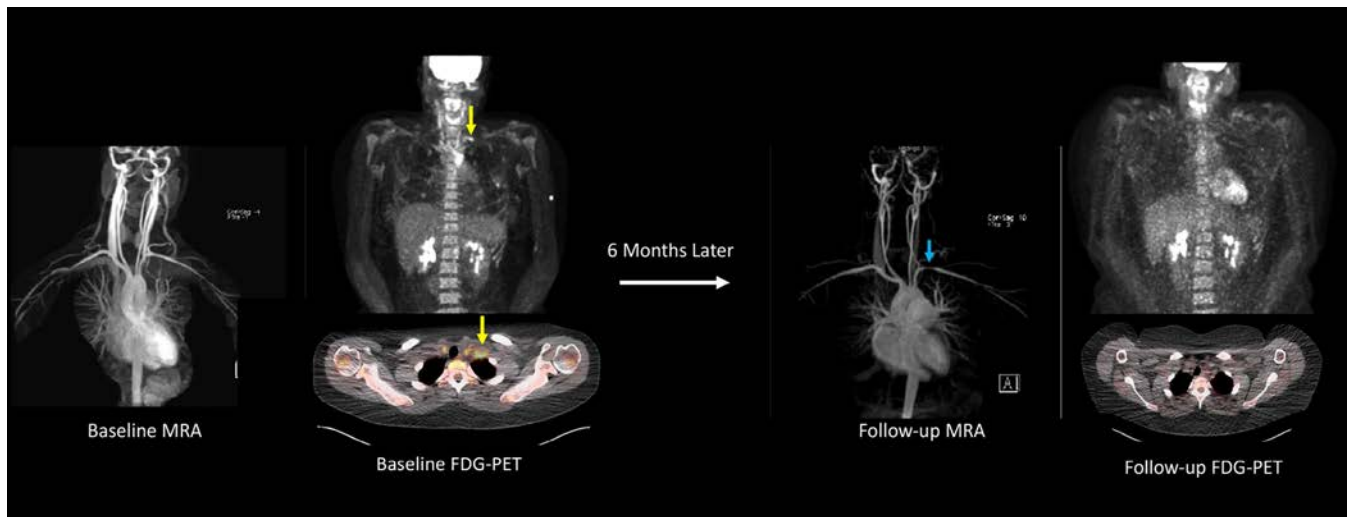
Baseline and follow-up magnetic resonance angiography (MRA) and ^{18}F -fluorodeoxyglucose-positron emission tomography (FDG-PET) scans from a 22-year-old woman with Takayasu arteritis who discontinued receiving methotrexate/infliximab after ~ 2 years of treatment and subsequently developed constitutional symptoms, frontal headaches, carotidynia, and left arm claudication 6 months later, with significant elevations in acute-phase reactants (erythrocyte sedimentation rate of 104 mm/hour, C-reactive protein of 85 mg/liter). A baseline FDG-PET scan showed severe vascular FDG uptake throughout the aorta and bilateral common carotid arteries with a prominent area of focal inflammation in the left subclavian artery (yellow arrows) on whole-body and axial views. MRA obtained the same date did not show vascular damage. Treatment was reinitiated with excellent clinical response. Six months after baseline imaging, the patient had a repeat MRA showing a new left subclavian artery stenosis (blue arrow) with resolution of vascular FDG-PET activity.
